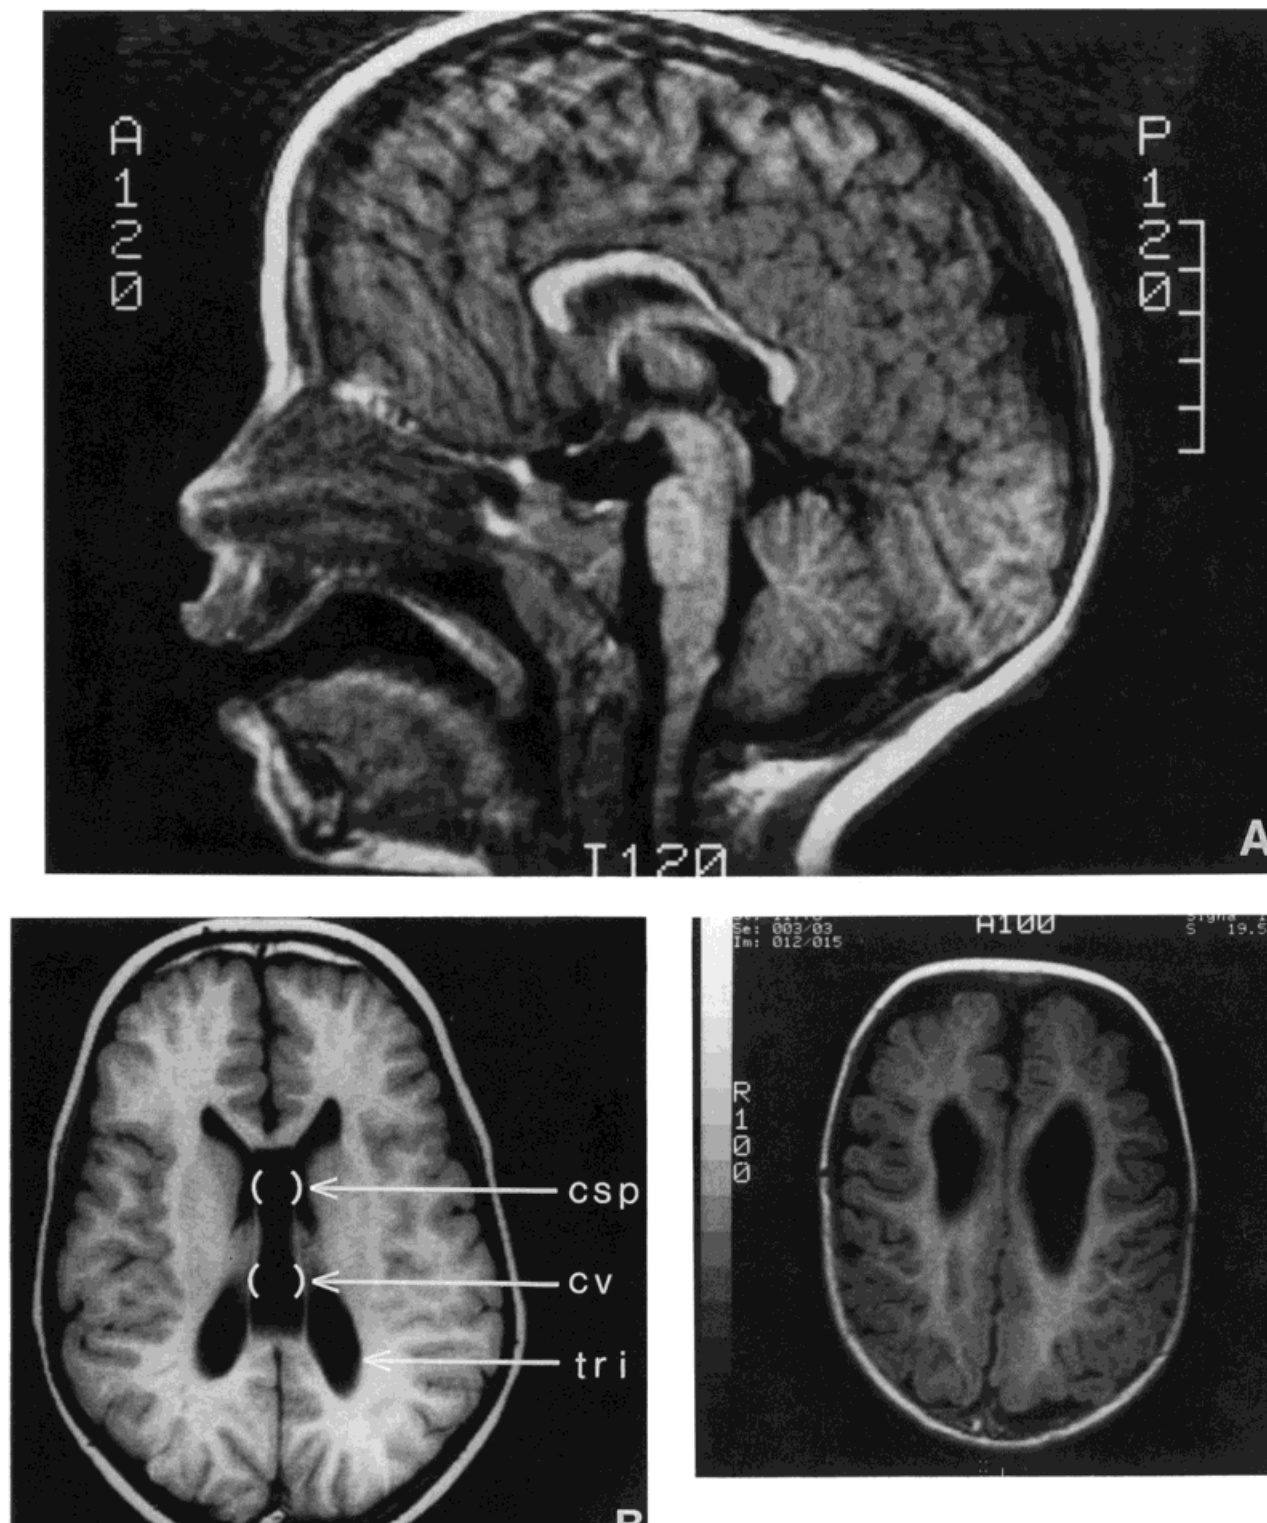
A: T<sub>1</sub> weighted midsagittal MRI image of a patient with Sotos syndrome showing thinning of the posterior portion of the body of the corpus callosum with relative preservation of the genu, rostrum, and splenium. B: T<sub>1</sub> weighted axial MRI image shows a prominent trigone region of the lateral ventricles (tri). There is also a cavum septum pellucidum (csp) and cavum vergae (cv) in this patient. C: T<sub>1</sub> weighted axial MRI image of the brain showing prominent cerebral subarachnoid spaces characteristic of Sotos syndrome. The gyri are particularly prominent in the anterior half and in the interhemispheric fissure between the frontal lobes.
